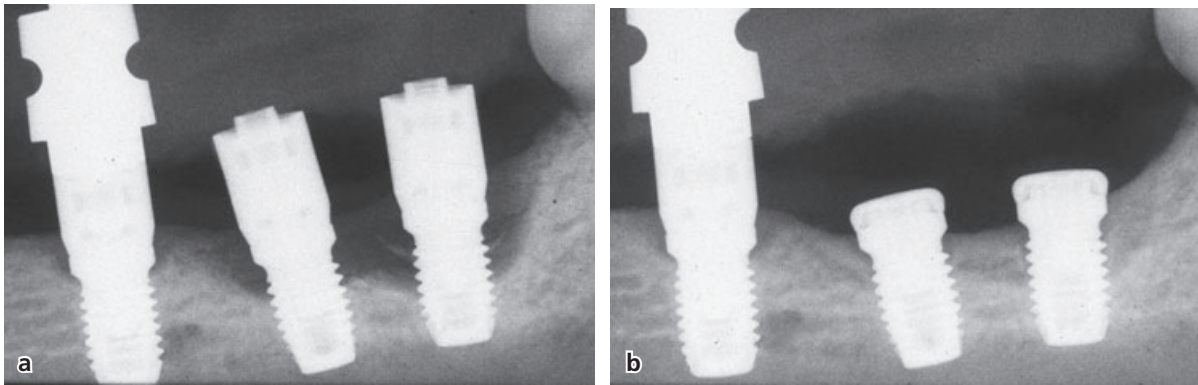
(a) Radiographs obtained from two sites exposed to experimental peri-implantitis. (b) The sites in (a) at 7 months of submerged healing after treatment of peri-implantitis. Note the bone fill in the previous osseous defects.
